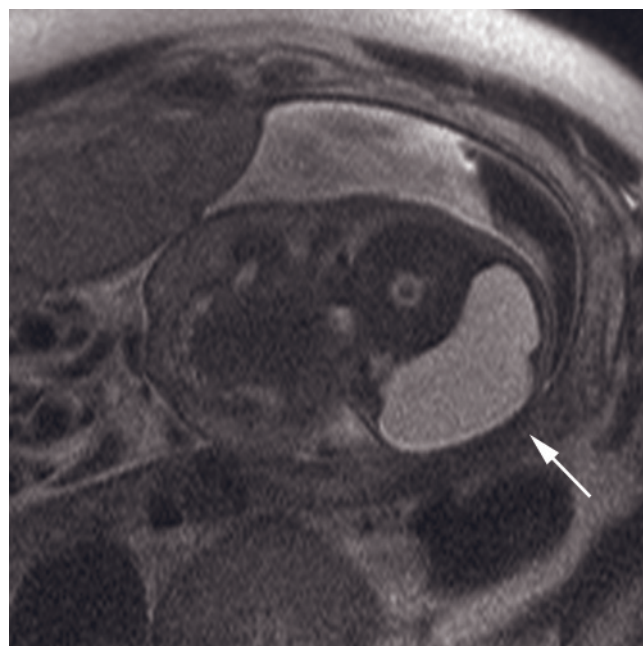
Intracranial teratoma. Coronal (a), axial (b), and sagittal (c) T2-weighted SS-ETSE images of the fetal head demonstrate a large complex intracranial mass with both cystic and solid components occupying the majority of the right cerebral hemisphere. There is resulting midline shift and hydrocephalus.
